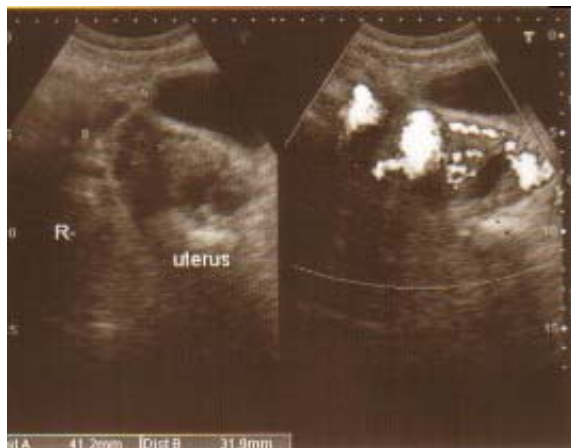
Doppler sonography of a vascular mass in the left adnexa.
